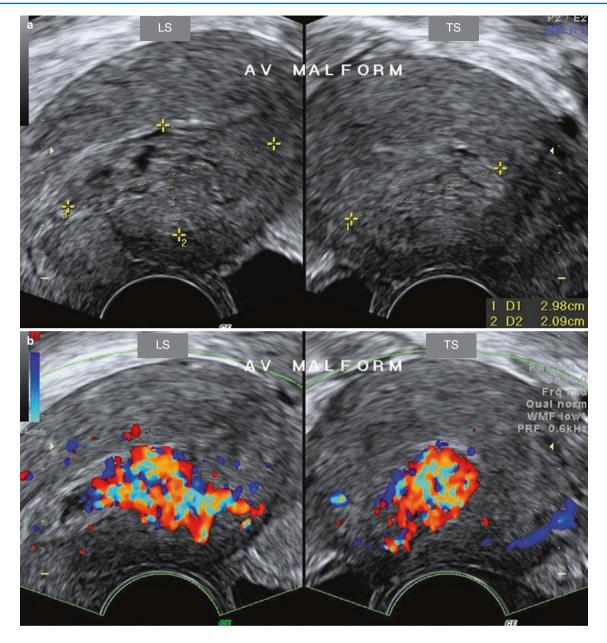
MTP with curettage was done 4 months ago. Patient presented with profuse bleeding for which this scan was done. B hCG on the day of scan was 35 mIU/mL. Patient was treated with methotrexate, and 2 months later B hCG came down to 0.22 mIU/mL and the lesion regressed on scan. (a) Heterogeneous ill-defined mass seen in the anterior myometrium extending into the endometrium. The endomyometrial junction in this area is poorly defined. On greyscale, margins of the lesion are difficult to define. (b) The lesion is seen filling up with colour and showing turbulent flow. (c) On TAS, the lesion with prominent arcuate feeder vessels is noted. (d) Flow showing high velocity and low resistance. (e) Repeat scan done 2 months later, when B hCG value was normal, showed that the lesion had regressed. A faint hyperechoic area is seen in the anterior myometrium which did not show any flow on Doppler
